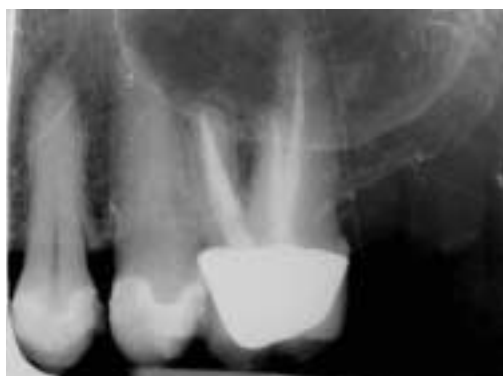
Periapical radiograph after 34 months.
